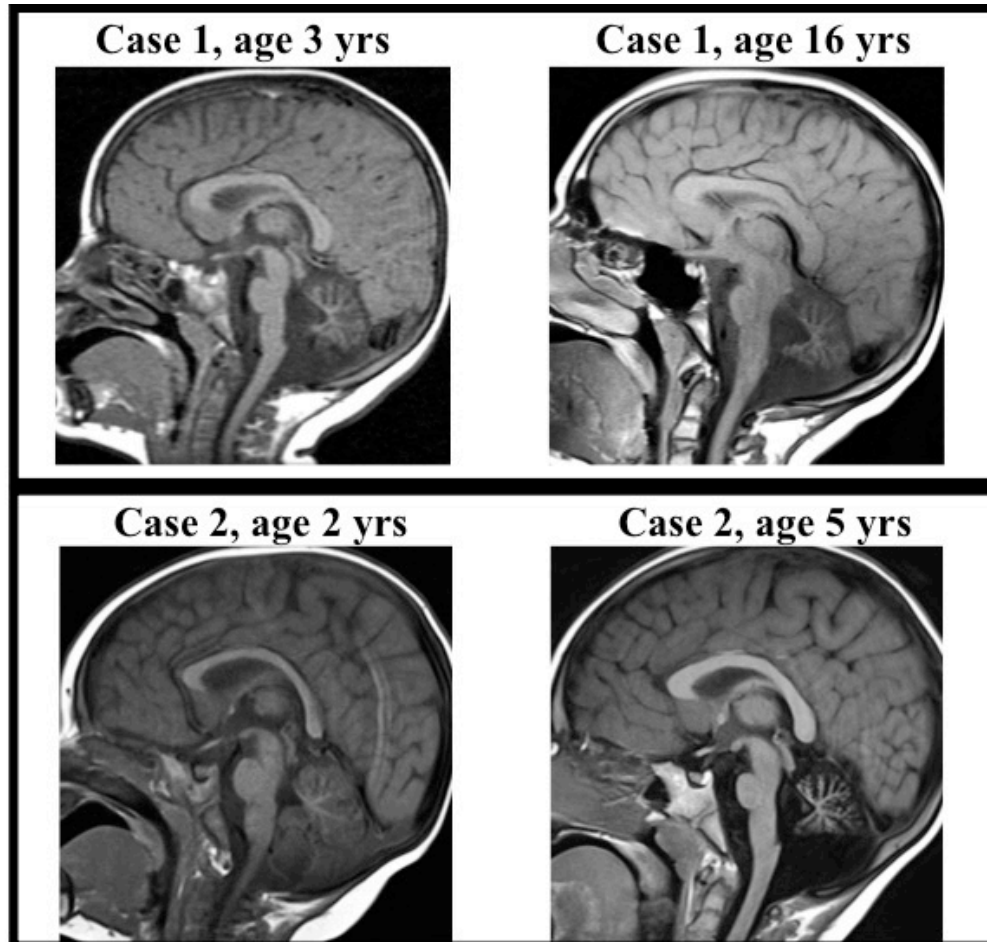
Progressive brain MRI images for Cases 1 and 2. Top panel: Brain anatomy of Case 1 at ages 3 and 16 years showing cerebral atrophy. Most of the cerebellar white matter has been lost with stable diffuse atrophy. Bottom panel: Case 2 at ages 2 and 5 years also showing cerebral atrophy and partial absence of the inferior portion of the cerebellar vermis.
